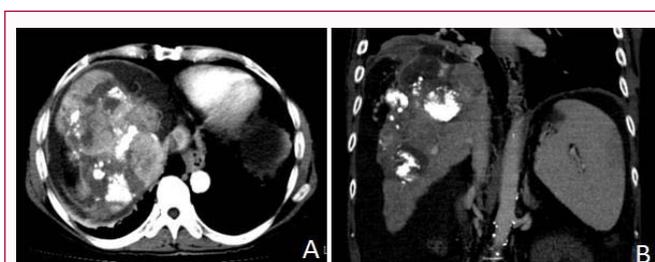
(A) Contrast-enhanced transverse CT imaging of ruptured hepatocellular carcinoma with associated hemorrhage 1 week after TACE. (B) Coronal CT imaging in the same patient.
